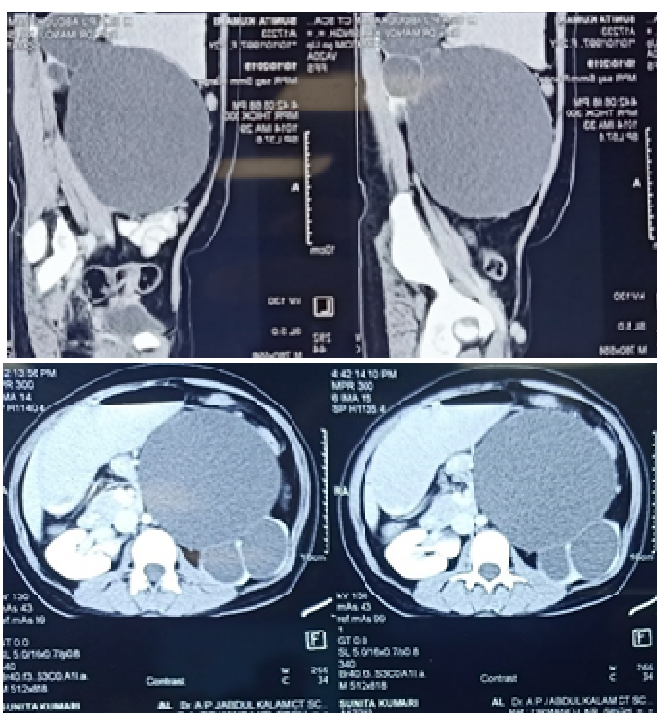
CT Images showing the abdominal lump
